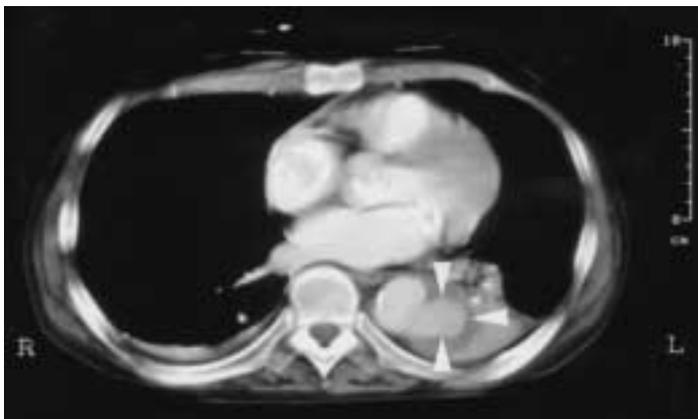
(a) CT scan demonstrating a pseudoaneurysm of the descending aorta. (b) Aortogram of a pseudoaneurysm arising from the descending aorta.
